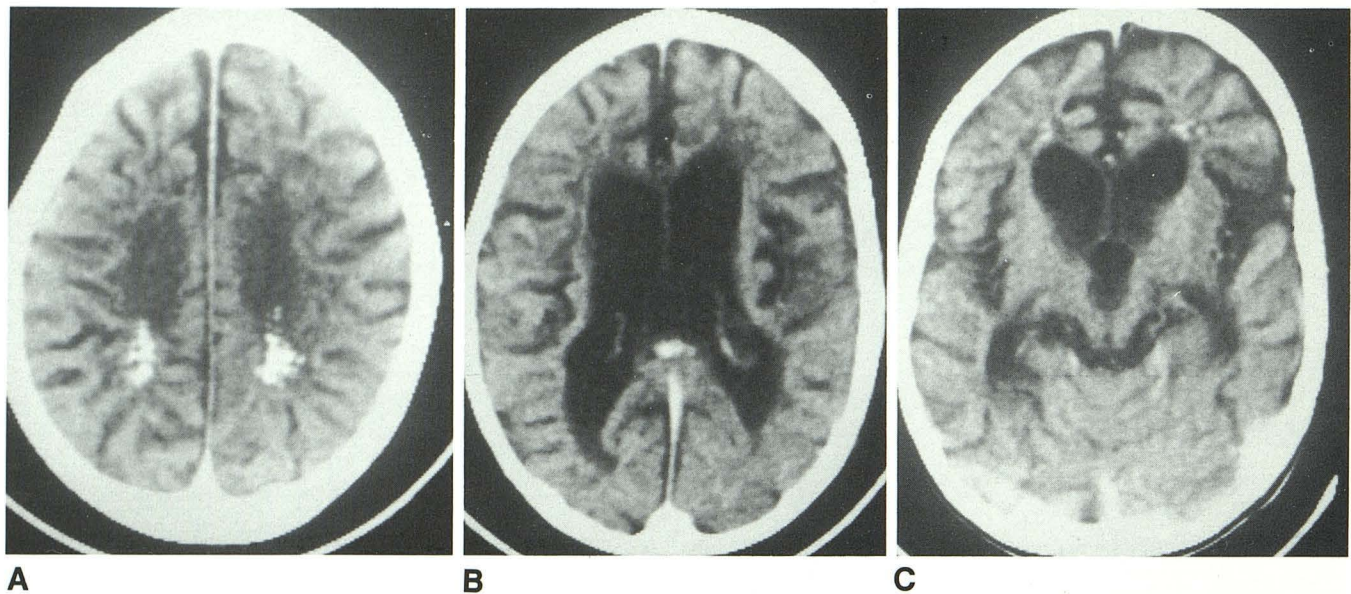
Adrenoleukodystrophy. Axial CT sections above the lateral ventricles (A), through the bodies of the lateral ventricles (B), and through the third ventricle (C). There is diffuse cerebral atrophy, a thin rim of low density in the periventricular white matter, and patchy calcification within the white matter adjacent to the superior borders of the trigones and frontal horns.
